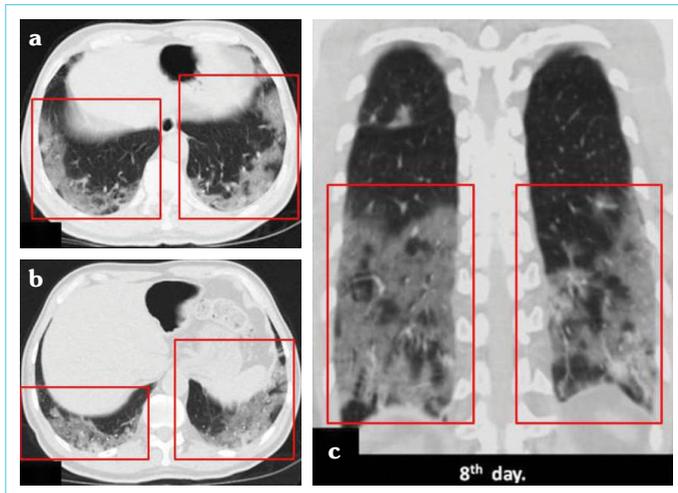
64-year-old man with a positive RT-PCR. Unenhanced thorax CT taken on the 8th day. The axial images (a, b) and a coronal reformatted image (c) show an increased diffuseness of opacities of ground-glass density with concomitant patchy areas of consolidation and interlobular septal thickening (red frames). These CT signs are compatible with stage 2 COVID-2 pneumonia
